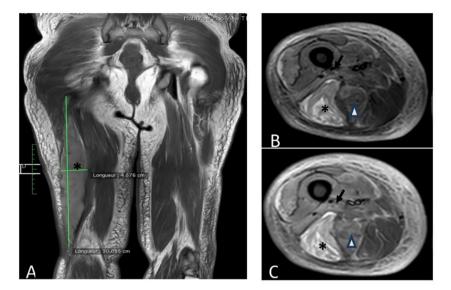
Case 5: MRI of the thighs in T1 (A) coronal sections, and axial STIR (B) and T1 Fat Sat with Gadolinium injection (C): Fusiform (asterisk) collection well limited developing in the intermuscular fascia between the two heads of biceps femoris muscle, in heterogeneous hyper signal STIR and T1 (measuring $30 \times 4.5 \times 6$ cm). It is associated with an infiltrated aspect of the surrounding fasciomuscular soft parts, particularly of the biceps femoris muscular body (Arrowhead). The collection comes in contact with the right sciatic nerve (arrow) to the middle third of the thigh. Fine collection under the fascia of the extensive lateral muscle dissecting the muscle mass of its fascia. Bilateral fatty degenetation on the thigh muscles predominant on the right.
